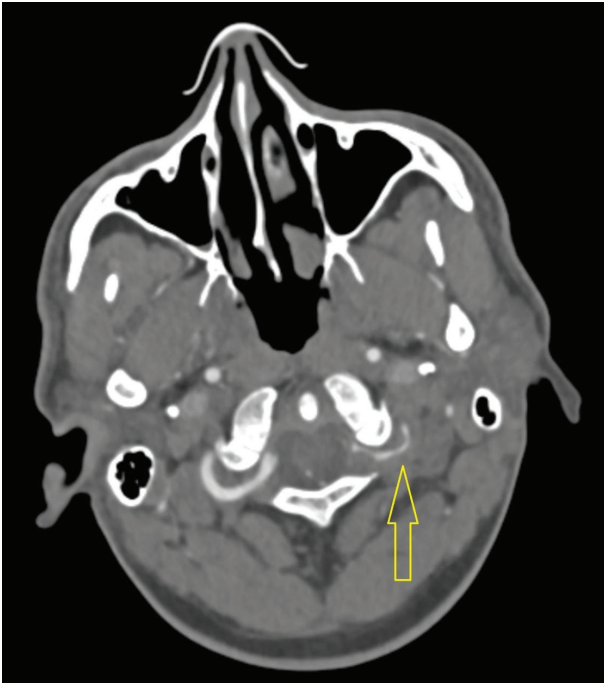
CT angiogram showing left vertebral artery narrowing and dissection.
